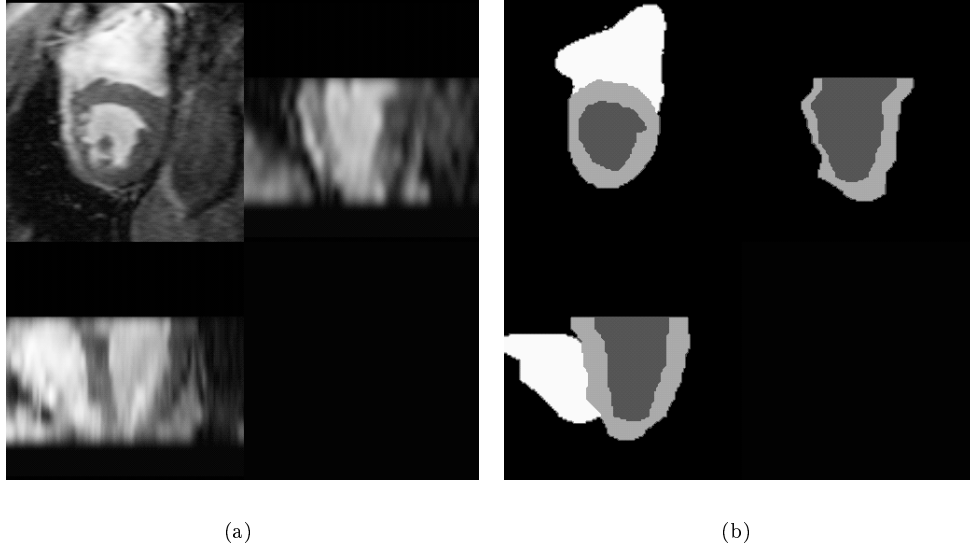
Example MR image and manual segmentation from the training set (three orthogonal views). The label images (Figure 7.3(b)) were manually extracted from three dimensional cardiac MR scans (Figure 7.3(a)) and subsequently interpolated using shape-based methods. In each slice the left ventricular blood pool (dark grey), the left ventricular myocardium (light grey), and the right ventricular blood pool (white) were manually outlined. The papillary muscles were included in the segmentation of the blood pool as is customary in clinical practice. The label image shown in Figure 7.3(b) has been resampled using shape-based interpolation. See the text for further details.
